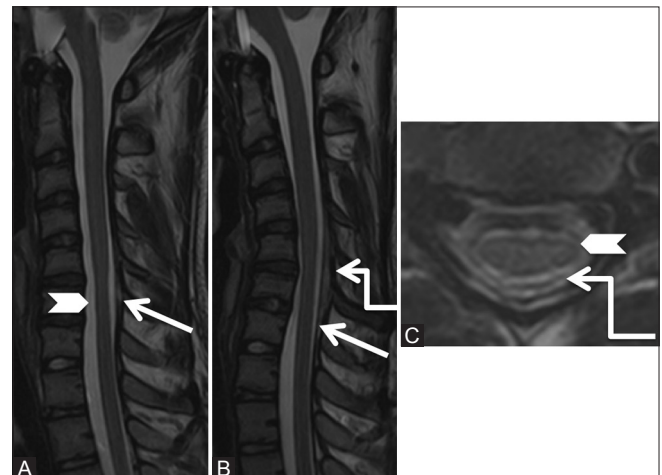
(A-C): Miscellaneous: Hirayama's disease: 15-year-old male had a history of progressive left upper limb weakness and wasting since 6 months. Sagittal T2-weighted images in neutral (A) position shows atrophy of the cervical cord from C5-7 levels (arrowhead) and subtle forward migration of the posterior dura (arrow), which is exaggerated in flexion (B) position. Axial T2-weighted (C) image at C5-6 level shows asymmetric atrophy of the left side of the cord (arrowhead), with widened posterior epidural space (elbow arrow)
